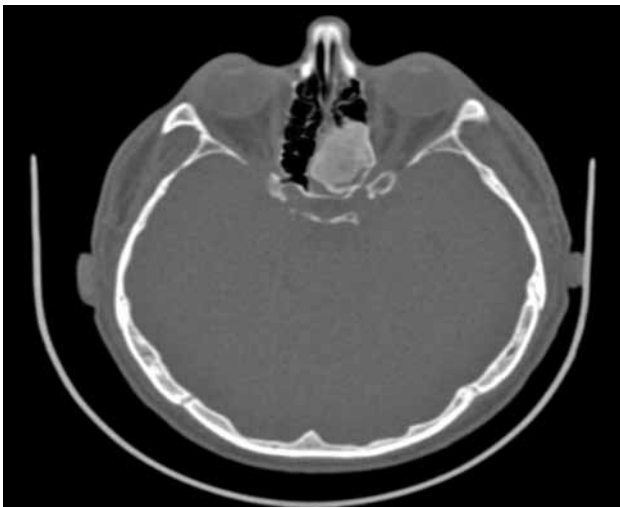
Axial computed tomography view of the osteoma in the sphenoid sinus.
